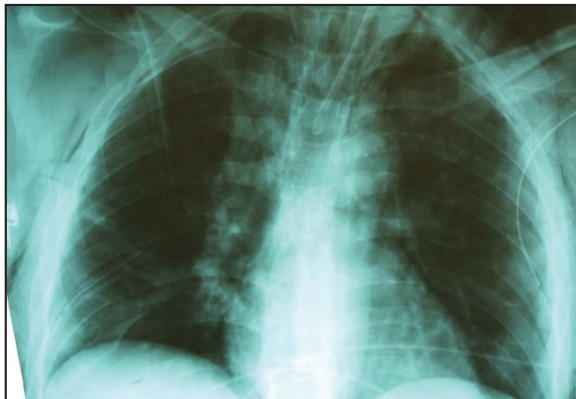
Chest x-ray which shows extensive bilateral subcutaneous emphysema and bilateral pleural effusion.
